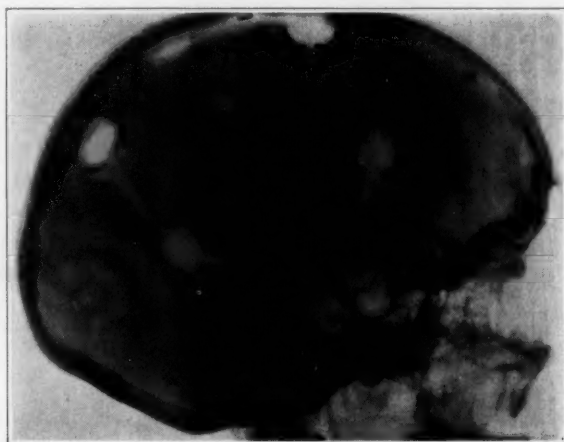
Lateral roentgenogram of the skull taken after operation. Silver clips applied to the margin of the defect produced at operation outline the area of extirpation. These are indicated by a ring of crosses. The other clips were applied to the dura mater.
